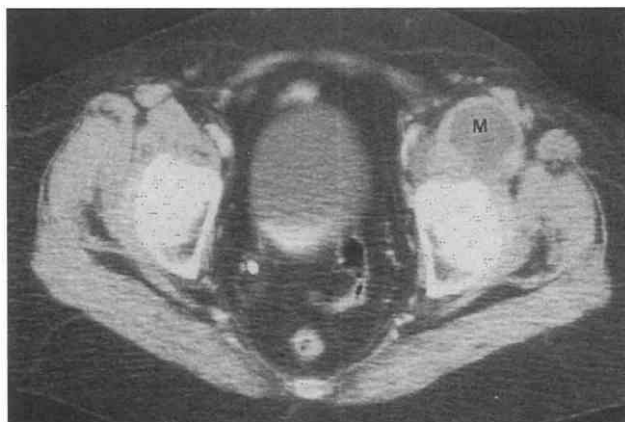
Enlarged iliopsoas bursa. Nondynamically enhanced CT scan shows an asymptomatic, low-attenuation groin mass (M) in a patient with rheumatoid arthritis. The mass represents an unusually prominent iliopsoas bursa.
